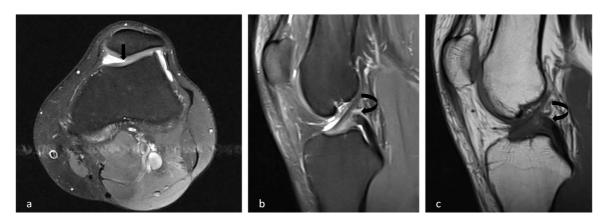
Type A Femoral trochlear dysplasia in 32 year-old- man. (a) axial proton density weighted MRI at 3 cm above the femorotibial joint space and trochlear groove is shallow (thick arrow). (b) sagittal proton density MRI with fat saturationand c sagittal T1 spin echo MRI showing normal anterior cruciate ligament (curved arrows).
